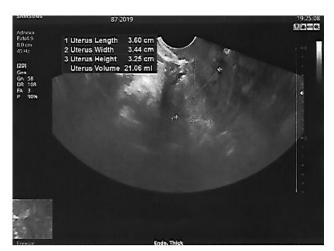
Patient 2. Transvaginal pelvic ultrasound, uterus, intrauterine endometrium
